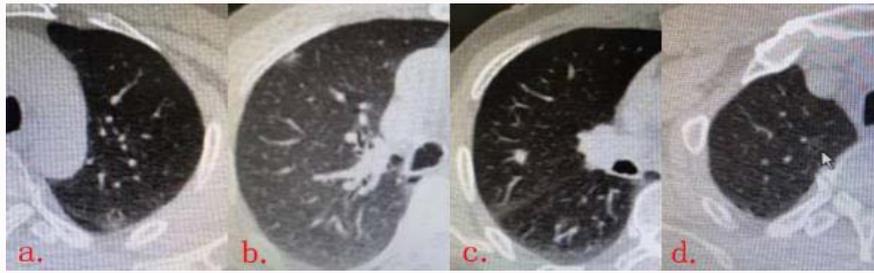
The CT images of pulmonary small nodules in 2016. (a) pGGN in apical or posterior segment of left upper lobe (13 mm). (b) part-solid GGNs in anterior segment of right upper lobe (6 mm, with solid components ≤ 4 mm). (c) Solid GGNs in posterior segment of right upper lobe (6 mm). (d) pGGNs in apical segment of right upper lobe (7 mm).
